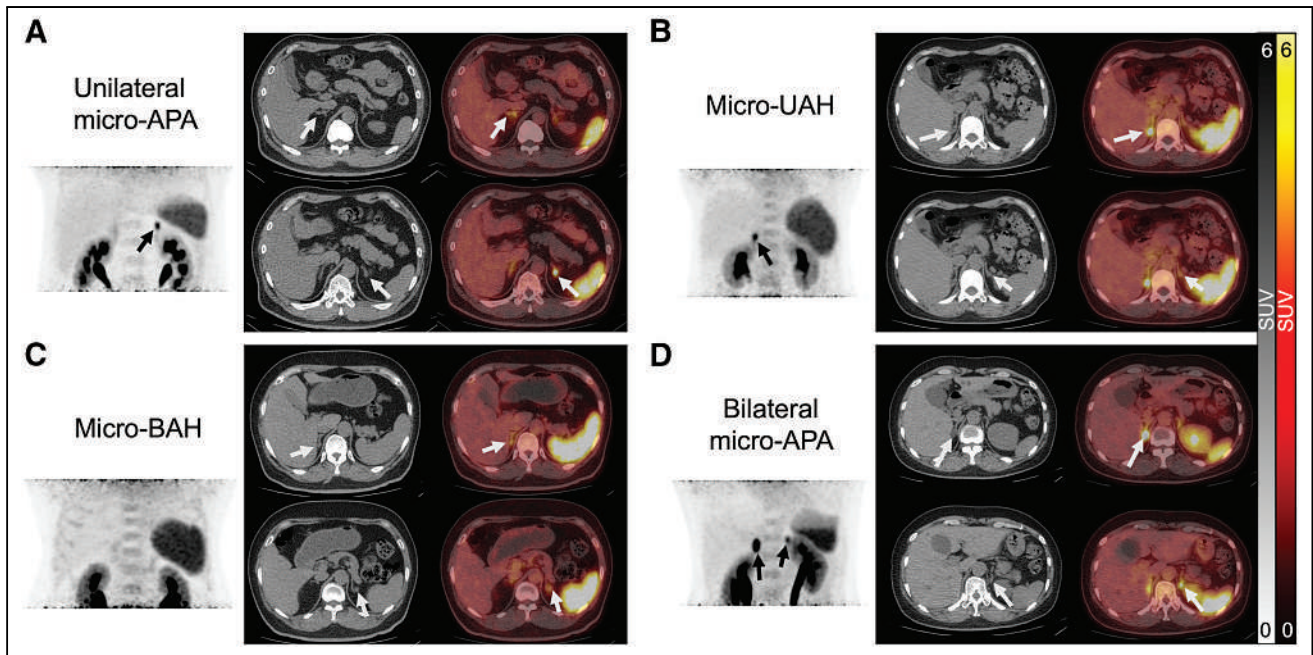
Performance of ^{68}Ga -pentixafor PET/CT in PA patients with bilateral microlesions on adrenal CT: unilateral micro-APA (A), micro-APA (B), micro-BAH (C), and bilateral micro-APA (D).
